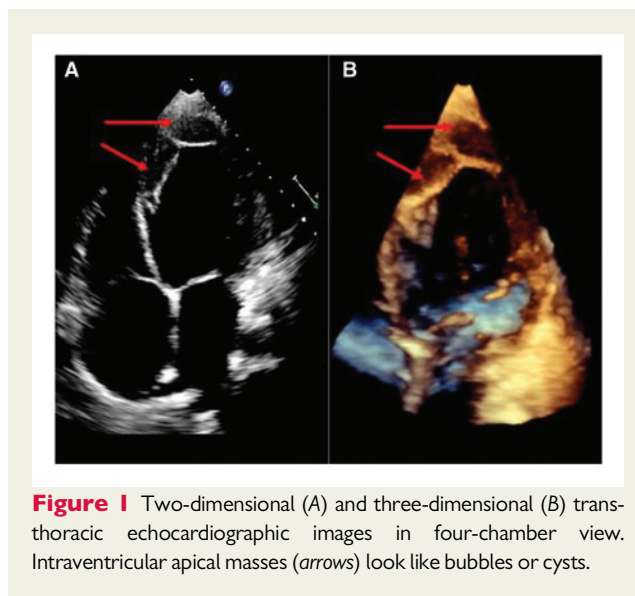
Two-dimensional (A) and three-dimensional (B) transthoracic echocardiographic images in four-chamber view. Intraventricular apical masses (arrows) look like bubbles or cysts.
